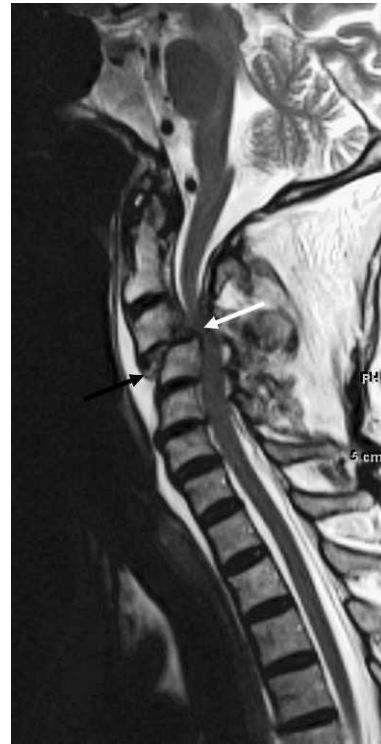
Ligamentous injury. Sagittal T2-weighted image showing injury to the anterior longitudinal ligament (black arrow) and posterior longitudinal ligament (white arrow) with subluxation and cord compression.
